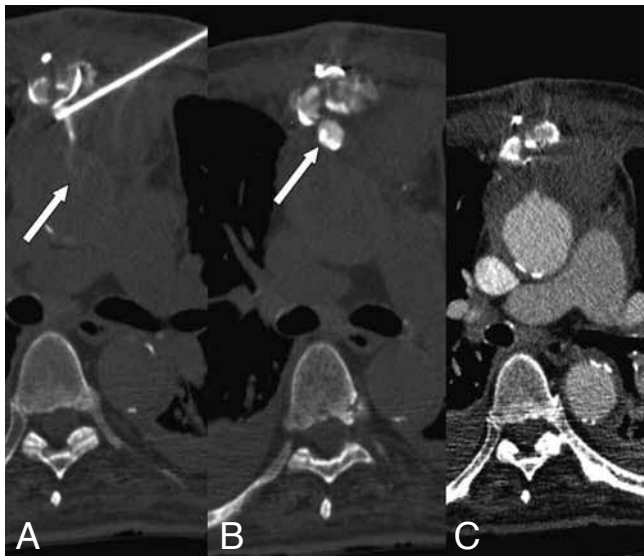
A demonstrates the tip of the needle in the pseudoaneurysm. Upon contrast injection through the needle, contrast is seen to enter the aorta (arrow) and pseudoaneurysmal sac (B, arrow). Post contrast CT after thrombin injection demonstrates occlusion of the pseudoaneurysmal sac (C).
